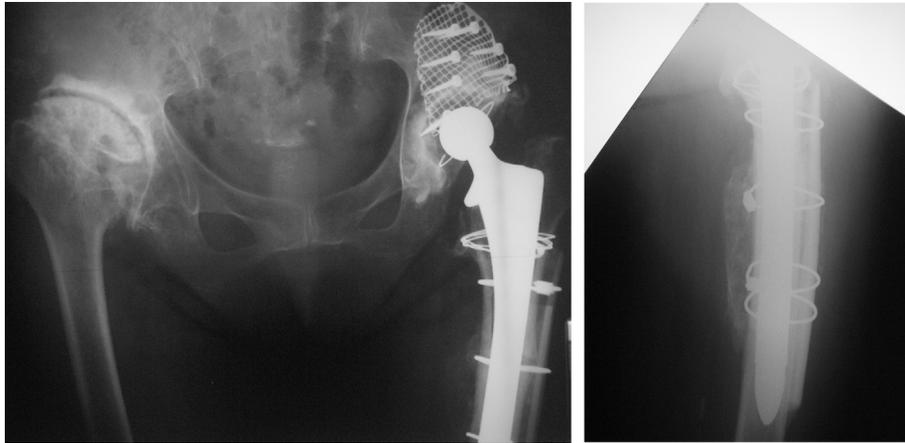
One year postoperative anterior–posterior radiograph showing healing of fracture and incorporation of bone graft.
